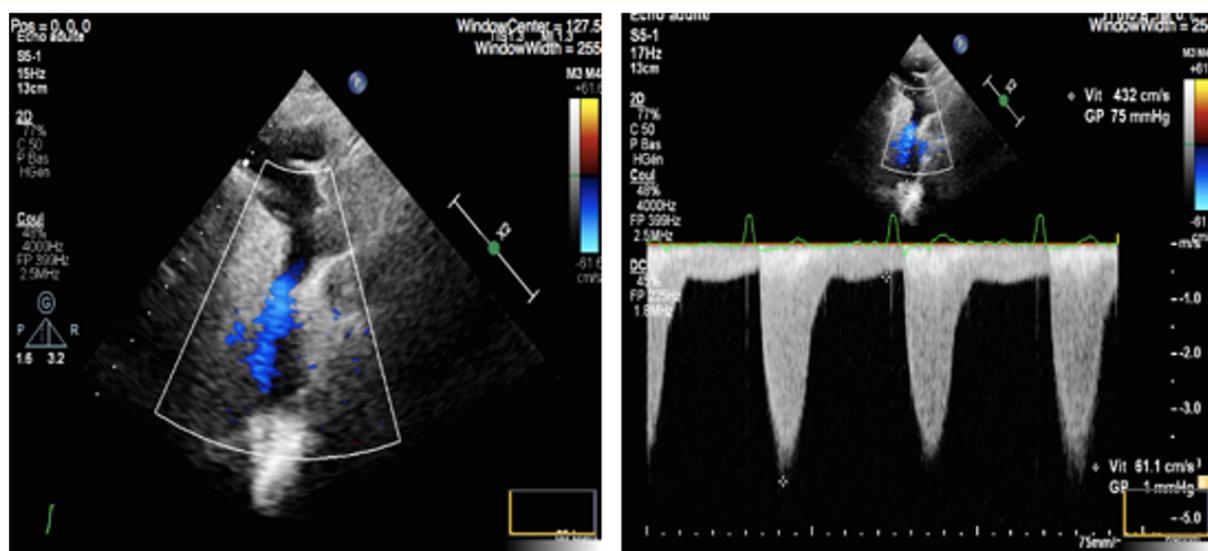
Transthoracic echocardiography suprasternal section shows a severe coarctation of aorta; the Doppler exam reveals a continuous flow with maximum of the velocity of 4,32 m/s.
